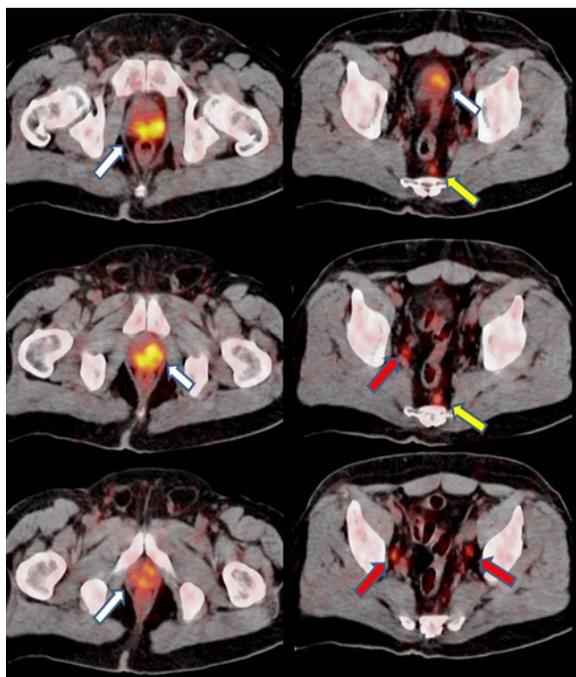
The PSMA PET/CT image of patient with prostate cancer showing intraprostatic tumor localization and lymph node metastasis. The white, red and yellow arrows show intraprostatic tumor localization, bilateral obturator lymph nodes, and perirectal lymph nodes, respectively on the PSMA-PET CT scan.
